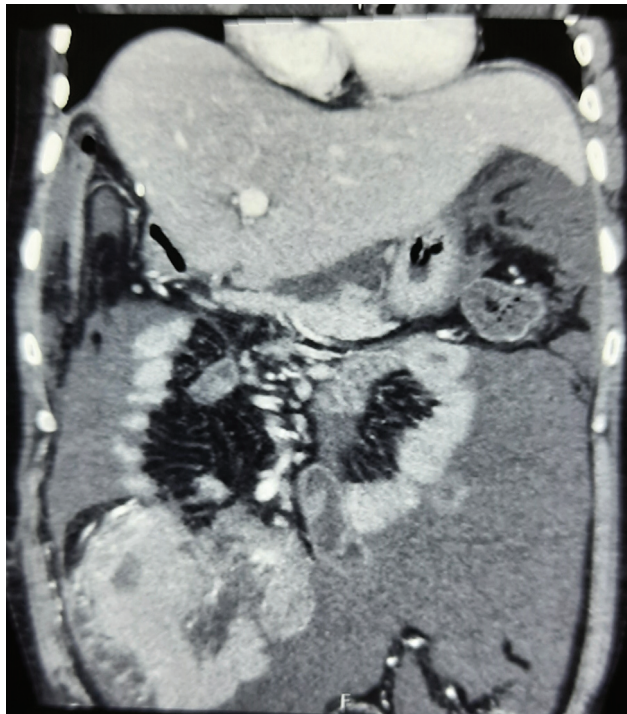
Contrast-enhanced computed tomography of abdomen showed mass lesion in right colon, involving cecum and ascending colon along with abdomen lymphadenopathy and ascites.
